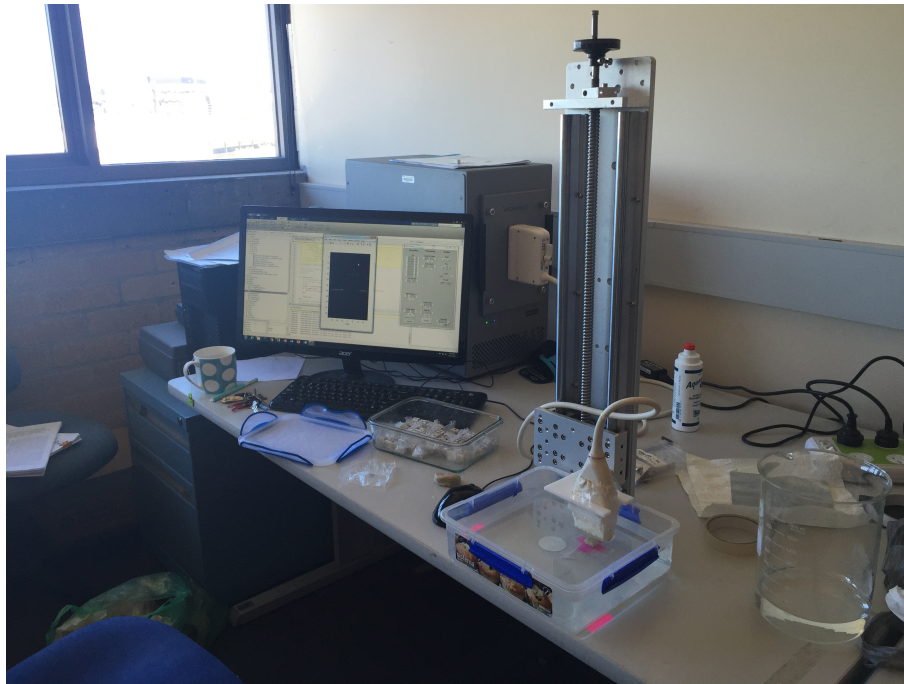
The Backscatter Measurement of Cancellous Bone using an Ultrasound Imaging System*
